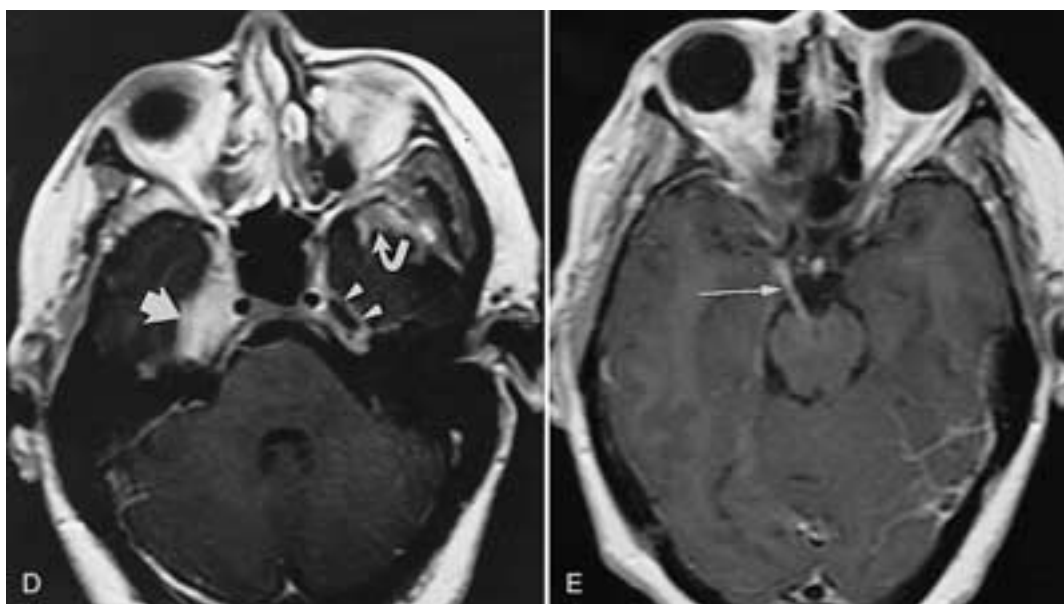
Continued. D, Enhanced axial T1-weighted (4501/11, TR/TE) MR image shows sarcoid granuloma involving the right Gasserian cistern (*large arrow*) and adjacent cavernous sinus, normal left Gasserian cistern (*arrowheads*), and abnormal enhancement in the left temporal fossa (*curved arrow*). E, Enhanced axial T1-weighted (450/11, TR/TE) MR image shows enhancement of the cisternal segment of the right third cranial nerve (*arrow*). The lateral gaze of the right eye is caused by the right oculomotor nerve palsy. (From Mafee MF et al. Sarcoidosis of the eye, orbit, and central nervous system. Role of MRI. *Radiol Clin North Am* 1999;37:73–87.)
